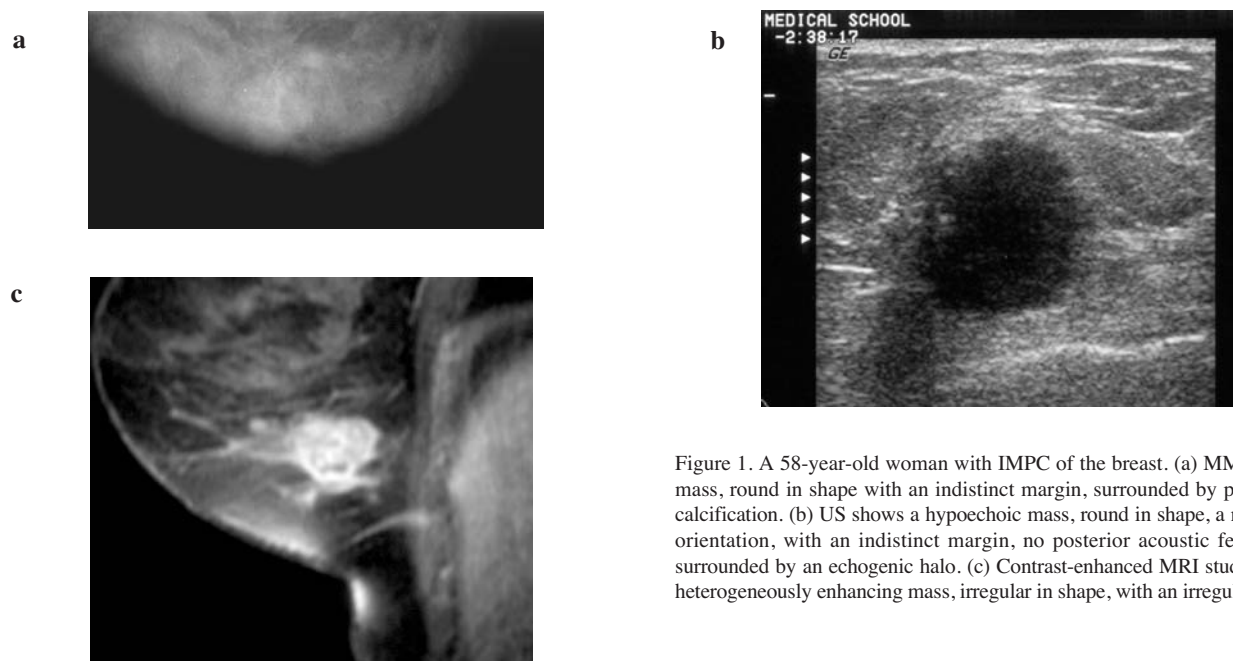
A 58-year-old woman with IMPC of the breast. (a) MMG shows a mass, round in shape with an indistinct margin, surrounded by pleomorphic calcification. (b) US shows a hypoechoic mass, round in shape, a non-parallel orientation, with an indistinct margin, no posterior acoustic features, and surrounded by an echogenic halo. (c) Contrast-enhanced MRI study reveals a heterogeneously enhancing mass, irregular in shape, with an irregular margin.
